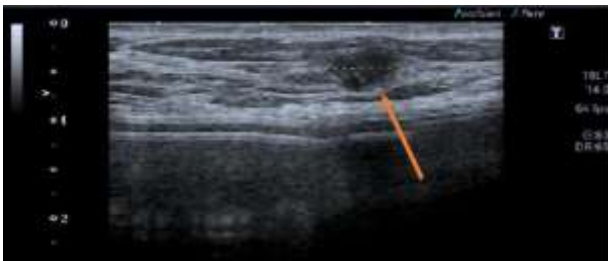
The ultrasound scan of the case report's patient; indeterminate lesion U3.
